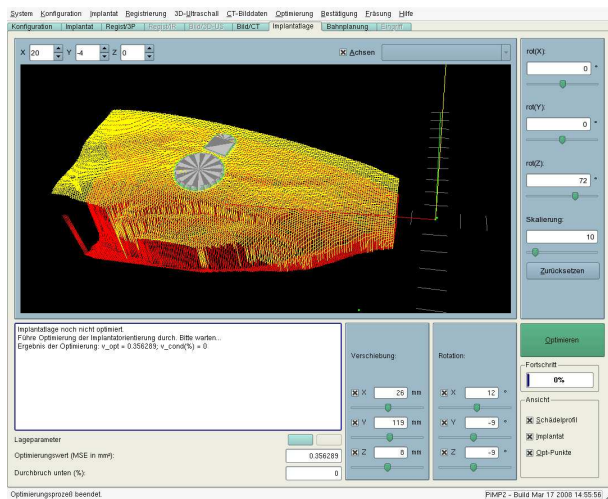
Screenshot of process phase "Implant Position Optimization" (with Soundbridge implant model and CT-based image data, after an automatic position optimization step).
